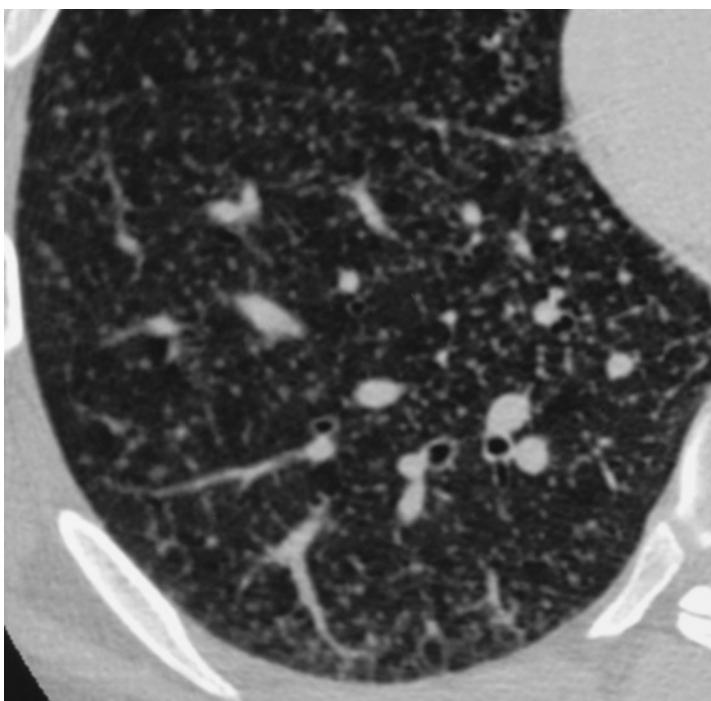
Miliary tuberculosis. The patient is a 33-year-old South American man presenting in the emergency room with circulatory collapse. A CT scan was ordered to evaluate findings of finely nodular shadowing on the plain chest radiograph. CT impressively demonstrates the diffuse, completely uniform distribution without any postural movement or predilection for the bronchovascular bundle, central lung, or periphery. There is no associated effusion or area consolidation.
